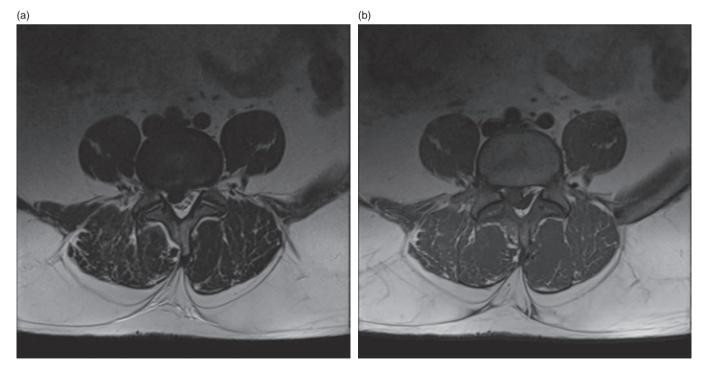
MRI scans (a) T2 Axial L4/L5 (b) T1 Axial L4/L5
